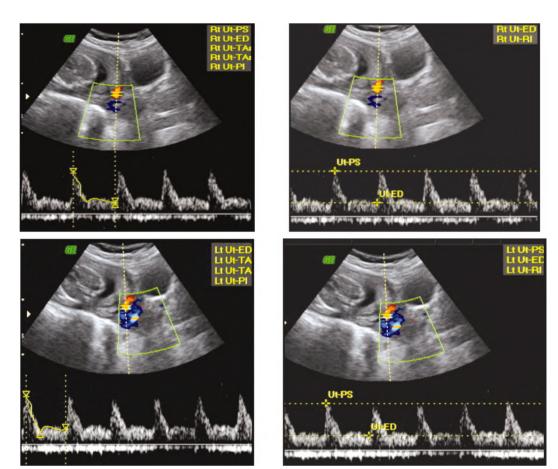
19-year-old female patient. During pregnancy, the patient developed hypertension. G1P0 was her obstetric code. By US, the patient's gestational age was 22w+1 ds and she had no recollection of her first day of LMP. The patient developed preeclampsia and went into labour prematurely. The right and left uterine arteries have normal RI of 0.81 and 0.80 respectively on a Doppler examination of both uterinearteries.
